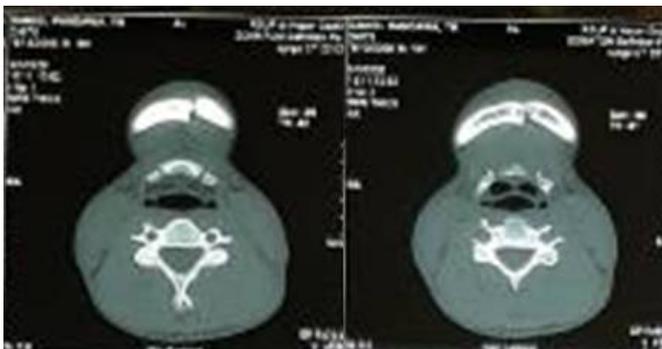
Axial CT Scan exhibiting fracture of symphysis mandible.
